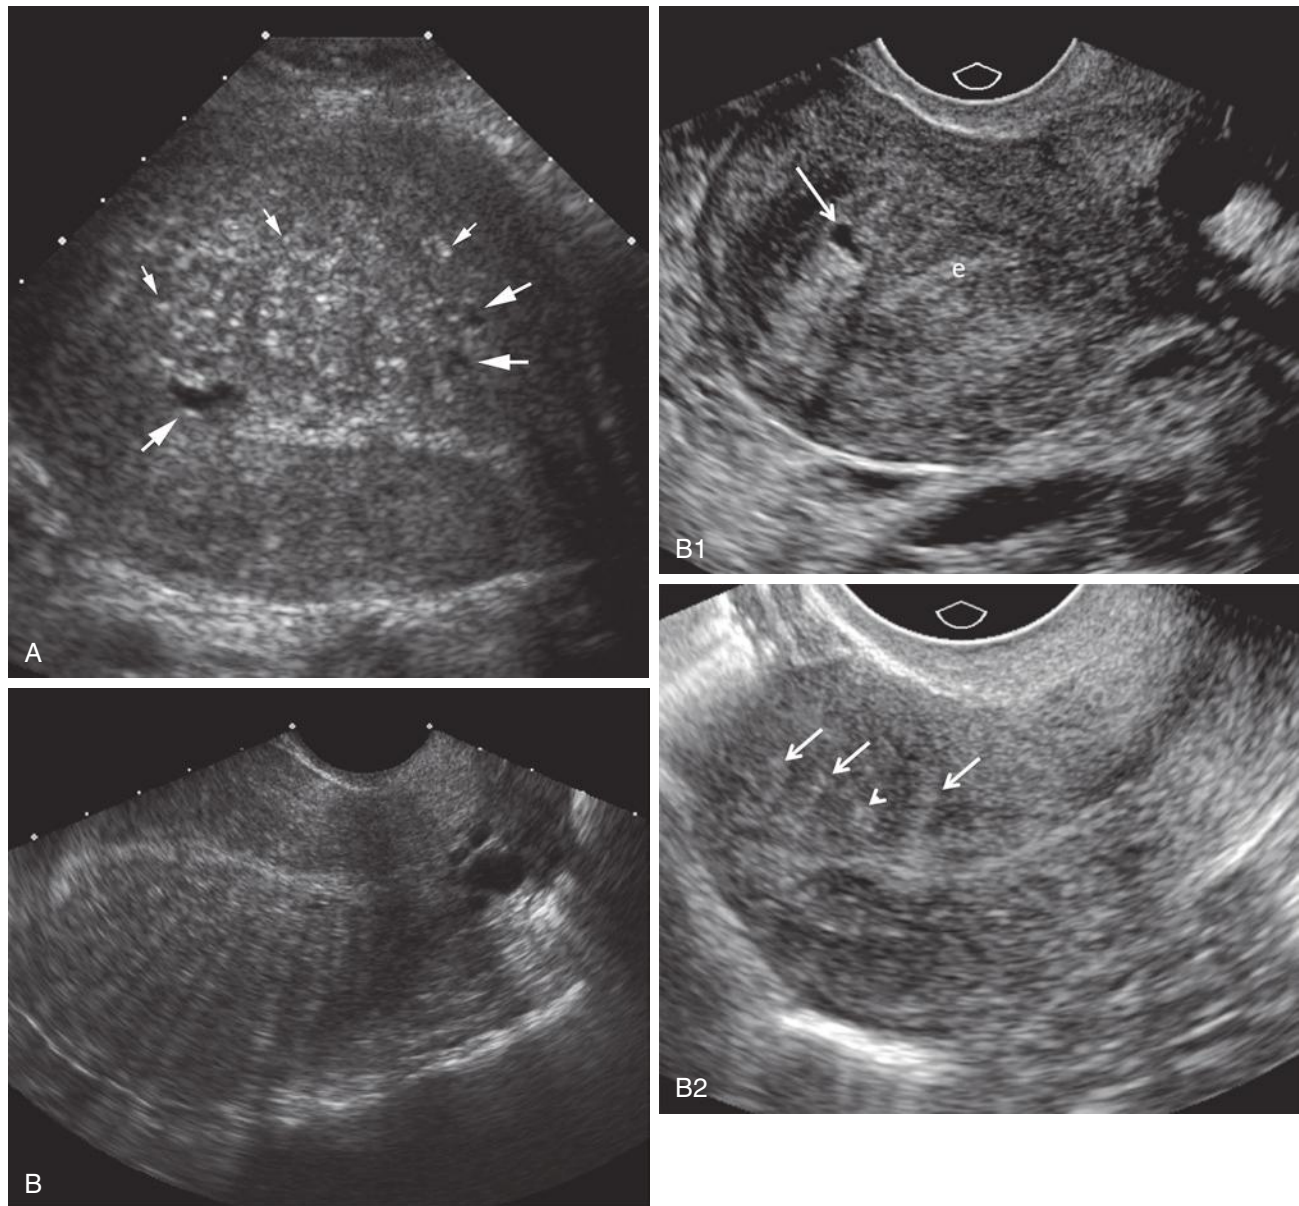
Adenomyosis: spectrum of appearances. A, Enlarged uterus with typical features of adenomyosis. Multiple bright echogenic foci are seen throughout the myometrium (*small arrows*) in addition to numerous subendometrial myometrial anechoic cysts (*large arrows*). B, Sagittal sonogram of the uterus demonstrating numerous thin hypoechoic, “venetian blind” or “comb-like” striations in the posterior myometrium. Although a similar pattern of striations may be seen with leiomyomas, the absence of a focal mass, the increased thickness of the posterior wall of the uterus compared to the anterior wall, and the presence of several small subendometrial myometrial cysts make this more characteristic of adenomyosis. B1, Sagittal transvaginal sonographic image demonstrating heterogeneity of the myometrium and two adjacent small myometrial cysts (*arrow*) with increased through transmission. Such myometrial cysts are believed to be a very specific finding for adenomyosis. e, endometrium. B2, Sagittal transvaginal sonographic image demonstrating heterogeneity of the myometrium, which is also relatively hypoechoic. Note several echogenic linear striations extending from the endometrium into the myometrium (*arrows*) and one nodular echogenic area (*arrowhead*) in the subendometrial tissue. A similar pattern of endometrial tissue extending into the myometrium can be seen on magnetic resonance imaging (MRI) and is believed to be another relatively specific finding for adenomyosis.
